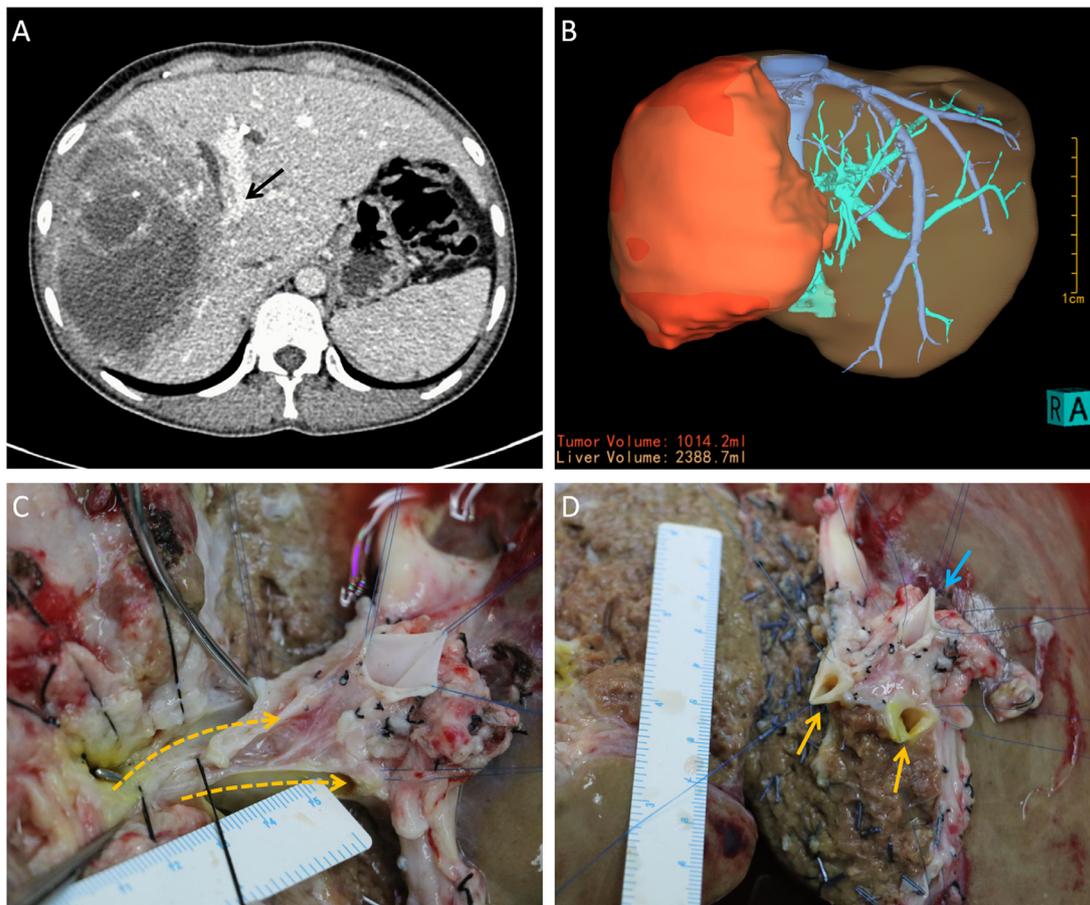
Preoperative images and intraoperative findings for a patient classified as P2H11, type IV. (A, B) Preoperative computed tomography (CT) and 3-D reconstruction suggested that the infiltration was confined to the left portal vein (PV) trunk. The sagittal portion of the left portal vein (LPV) was intact (black arrow). (C) Dissection of the Glisson system of the left lateral lobe is presented. The lesion infiltrated along the left branch and invaded the side wall of the two bile ducts (BDs; yellow arrow), which was not detected by preoperative imaging assessment. (D) Completion of radical resection is presented. A stump of the PV (blue arrow) and two stumps of the BD remain.
